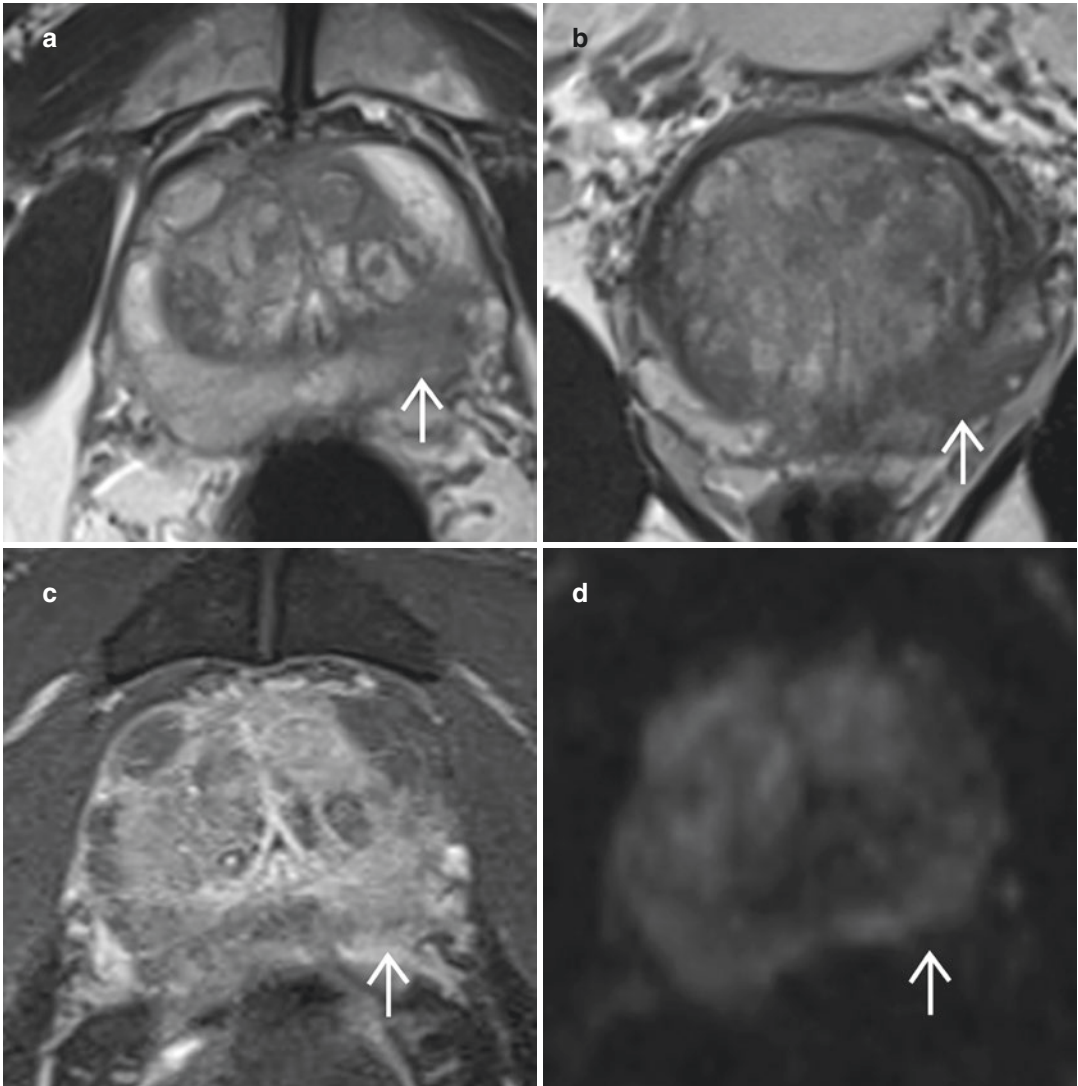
Prostatic TB in a 64-year-old asymptomatic man who had a mild elevation of serum prostate-specific antigen (12 ng/mL) during his annual health check. (a) Axial and (b) coronal T2-weighted and (c) axial contrast-enhanced fat-suppressed T1-weighted MR images show a rectangular-shaped, T2-hypointense focus with moderate
